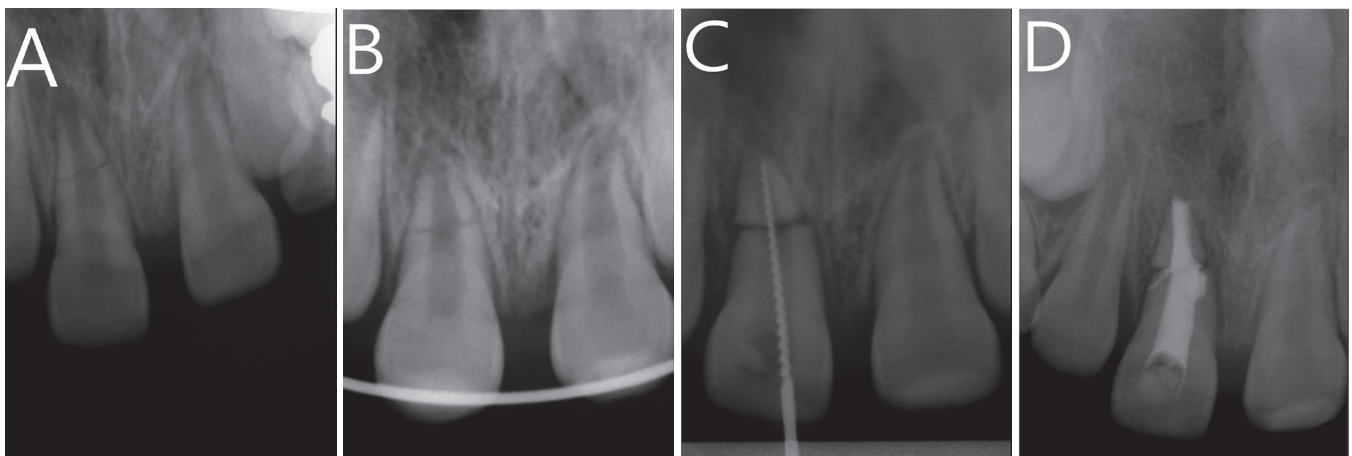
Periapical radiographs of a root fracture. (A) Initial periapical view. (B) Reduction and wire-splinted root-fractured tooth. (C) Pulp extirpation and (D) Calcium hydroxide canal filling were performed after 2 months.
